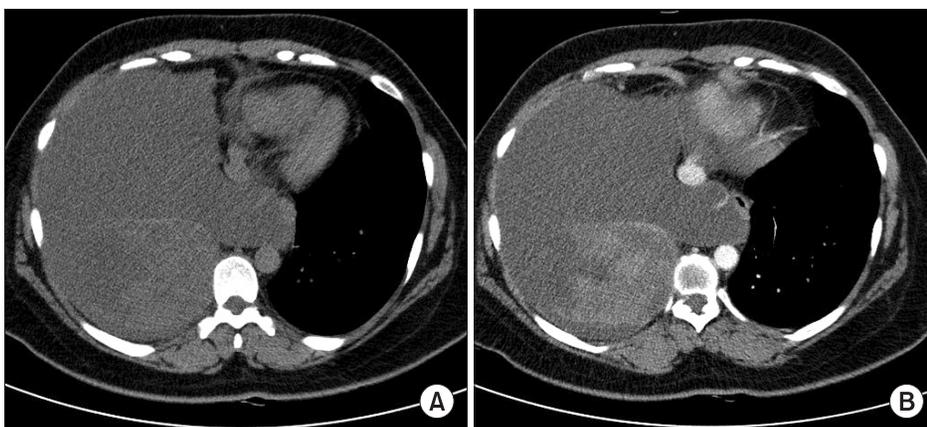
Pre- and post-contrast chest computed tomography (CT). (A) Pre-contrast chest CT revealed massive pleural fluid collection in the right lung with near total, passive atelectasis. (B) With contrast enhancement, relatively well-circumscribed mass was found in the posterior portion which showed minimal and inhomogeneous enhancement with radio-contrast dye.
